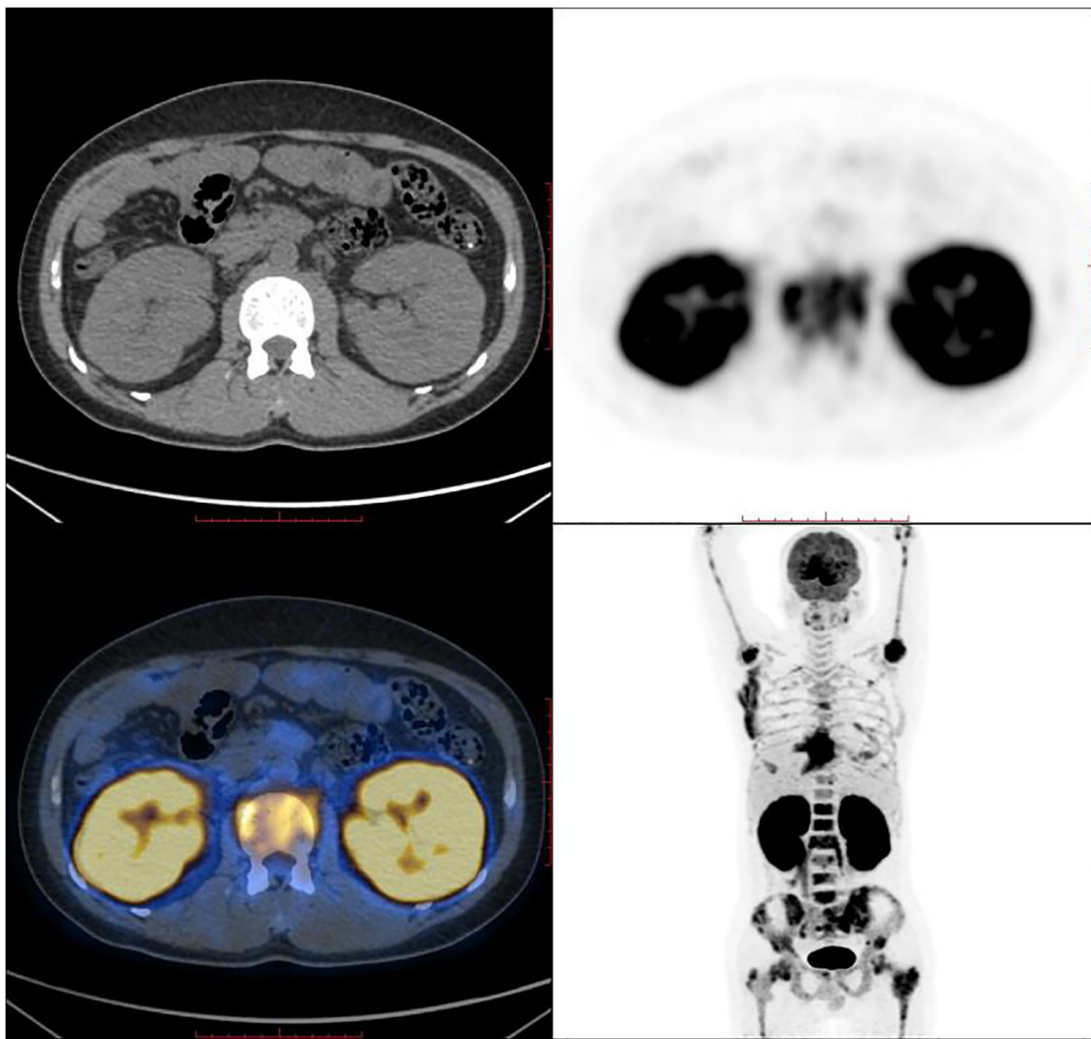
18F-FDG PET-CT findings. 18F-FDG PET-CT revealed bilateral diffuse renal enlargement with increased metabolism and extensive, localized increased bone metabolism throughout the body. 18F-FDG, 18F-fluorodeoxyglucose; PET-CT, positron emission tomography-computed tomography.
